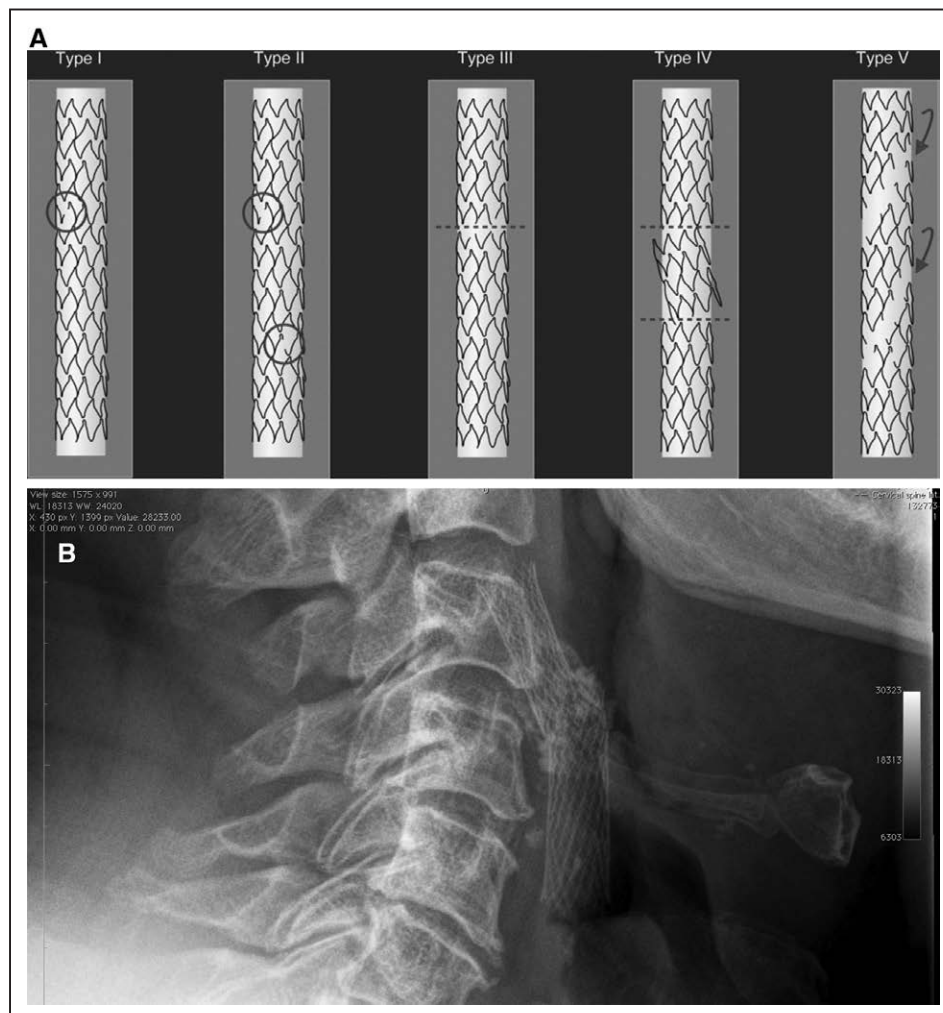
A, Stent integrity grading scale. B, Lateral x-ray of the neck depicting a grade IV stent fracture.
